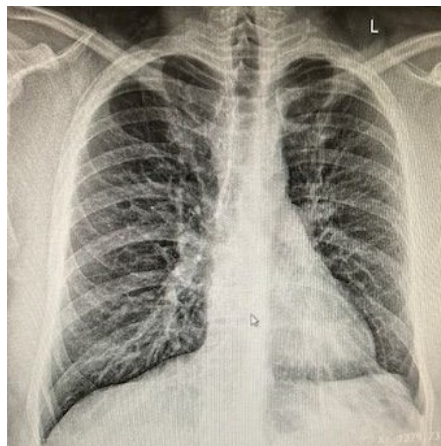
The chest radiograph shows bilateral interstitial changes.
